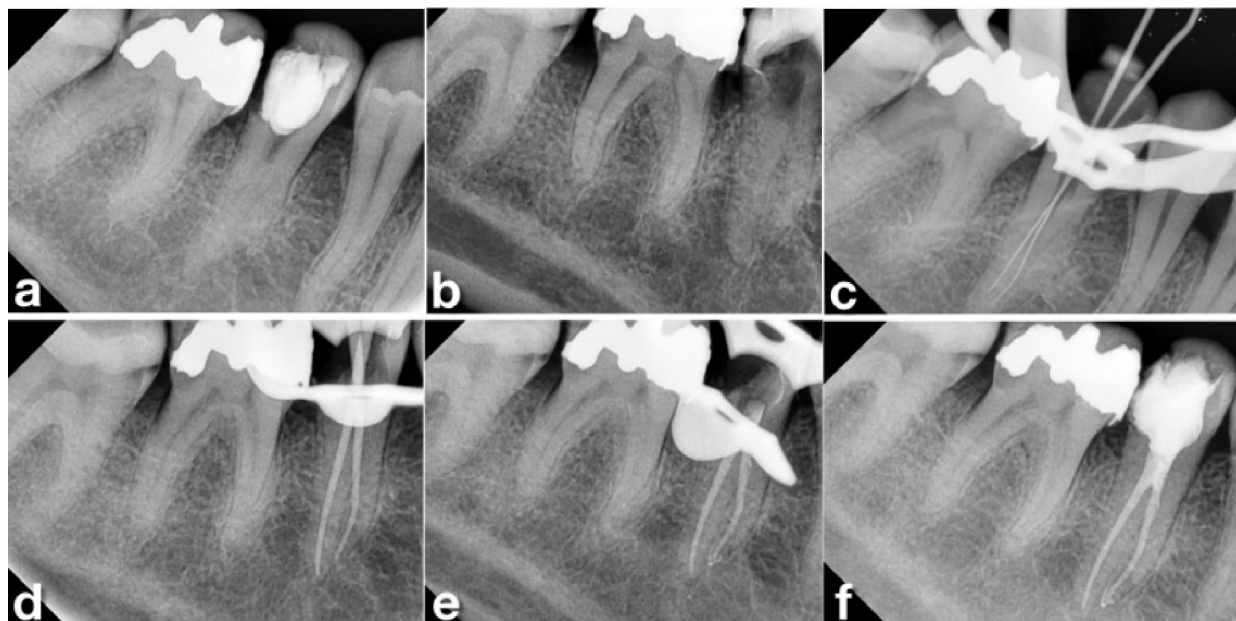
Case 3: a,b, preoperative radiograph (straight and mesial shift). c, working length radiograph. d, master cone radiograph. d,e, Postoperative radiograph (straight and mesial shift).
